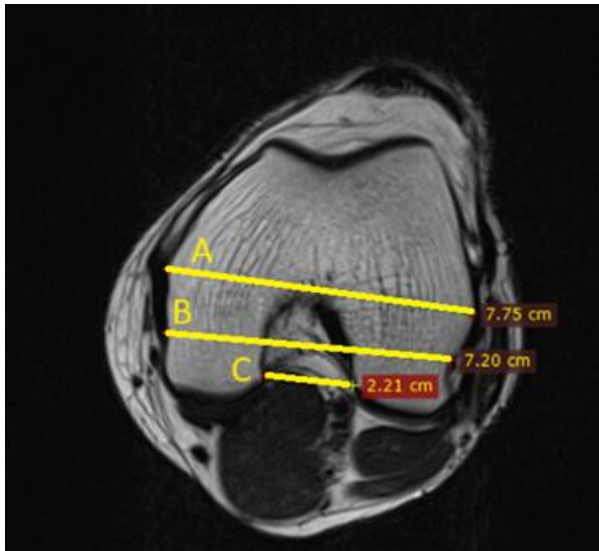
MRI knee T2 weighted axial slice: (A) measurement of trans-epicondylar length, (B) posterior condyle length and (C) notch outlet length.
